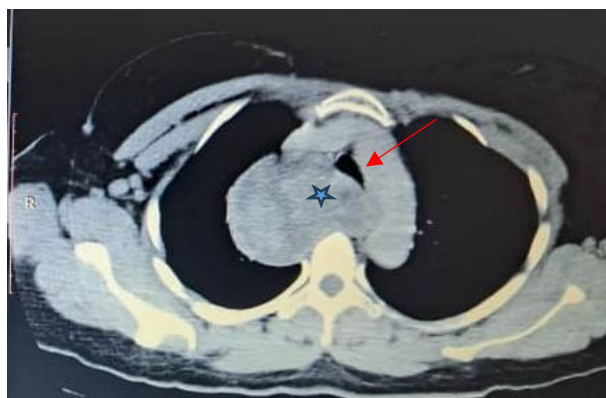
Pre-operative chest CT scan axial view- mediastinal goitre (Blue star) compressing the trachea (Red arrow)
